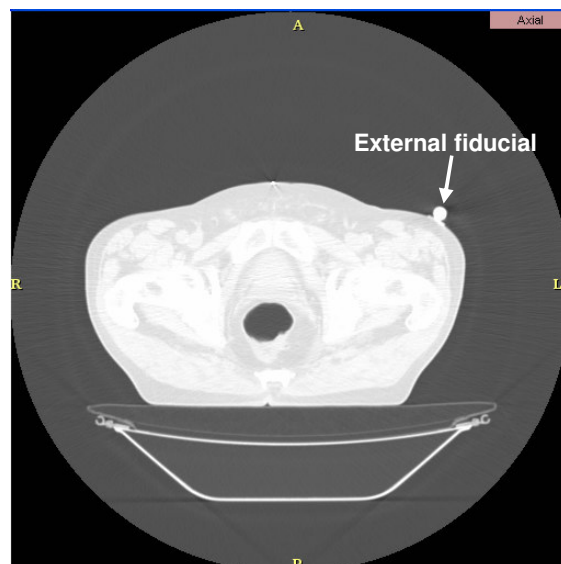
Axial CT slice for patient 1, showing one of the external fiducials used for set-up monitoring
